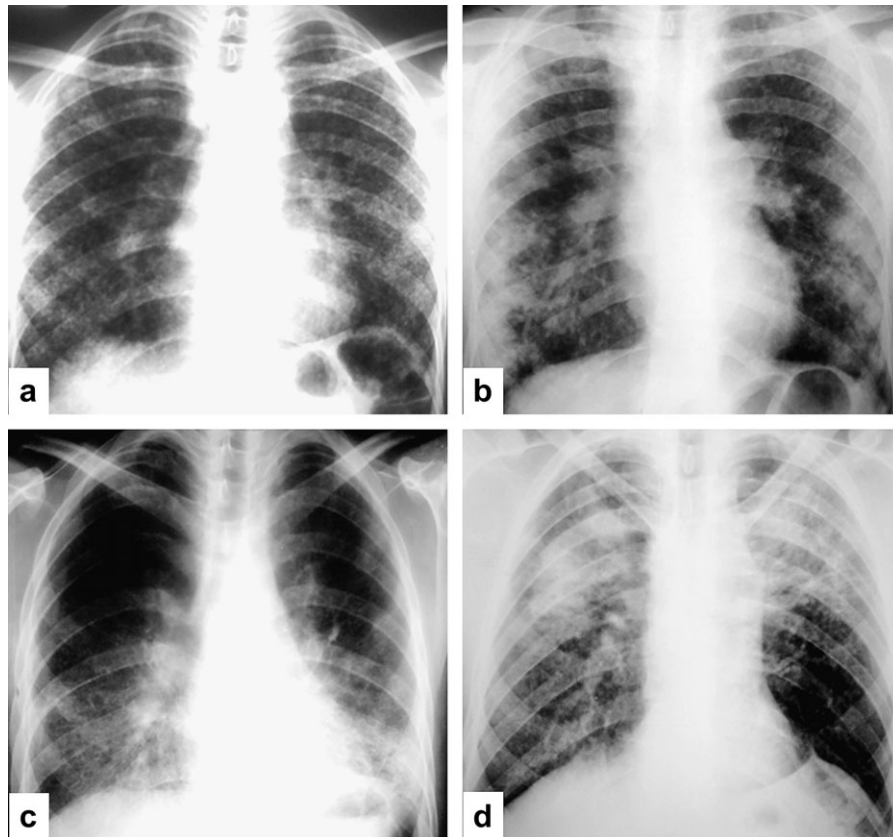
Chest X-ray imagings of Case 5 (a), 7 (b), 8 (c) and 12 (d), in which there are more prominent findings than others, show bilateral interstitial infiltrates, which are prominent in the lower zones (a), large opacities located predominantly peripheral (b) and in the upper zones (d) and fibrotic changes in the lower lobes (c).
